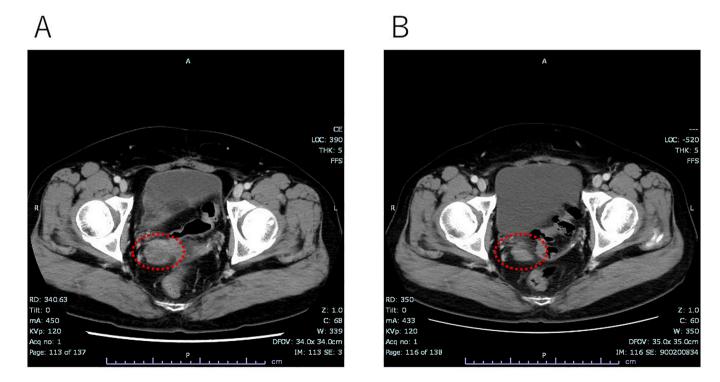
Comparison of computed tomography findings at the start of eribulin administration and at present. (A) The tumor was present at the vaginal cuff, and the size was $26 \times 25 \times 15$ mm at the start of eribulin treatment. (B) The tumor has gradually decreased to $20 \times 12 \times 11$ mm at present.
